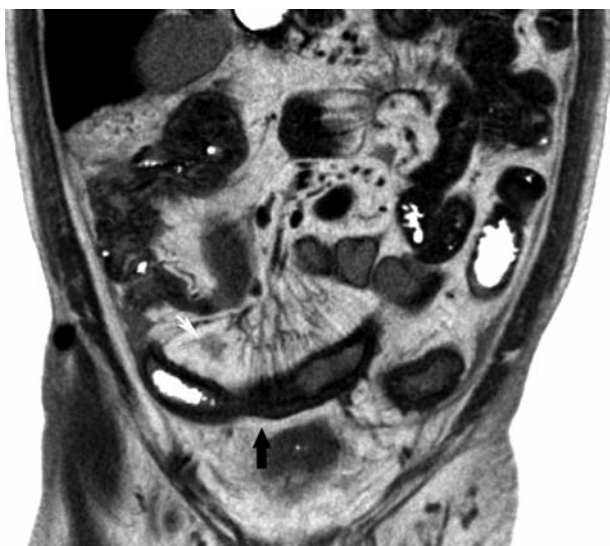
Abdominal computed tomographic scan showing a 20-cm long segment in the distal ileum, having thick walls with a central stricture (black arrow). An inflammatory mass can be seen in the mesentery (white arrow).
